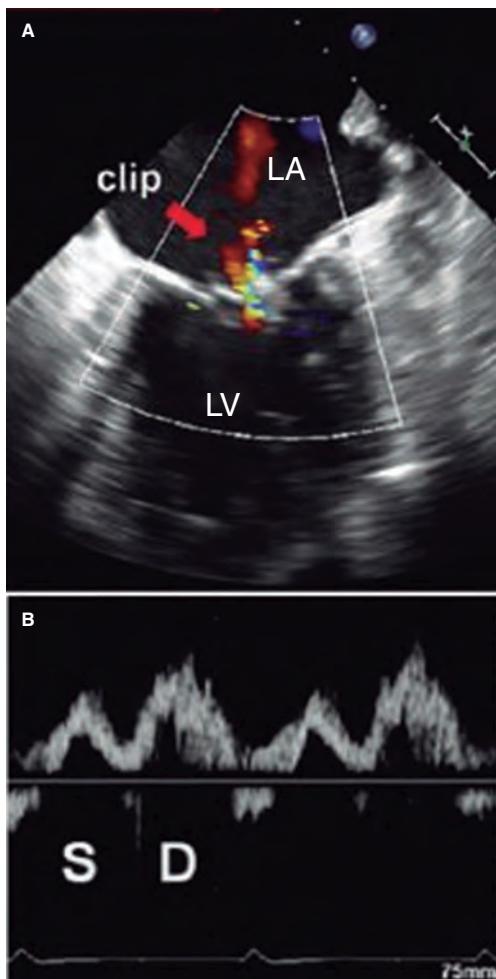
Two-dimensional transesophageal echocardiography image. A: color Doppler of residual mitral regurgitation after clip implantation (arrow). B: the corresponding blood flow at left upper pulmonary vein level is exposed with systolic (S) wave attenuation with respect to the diastolic (D) wave. The systolic velocity-time integral is 7.5 cm, and the diastolic one, 14 cm. The ratio between the 2 is 0.54, indicative of a higher risk of major adverse cardiovascular events. In this case, clip implantation is suboptimal. LA, left atrium, LV, left ventricle. Reproduced with permission from Ikenaga et al.²⁸
